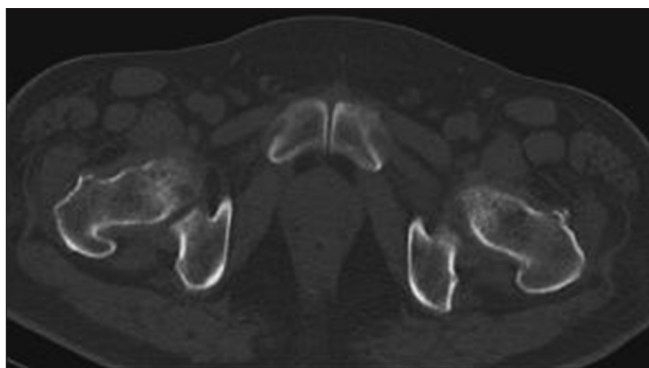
Axial computed tomography showing minimal sclerosis in the right femur and left pubis
